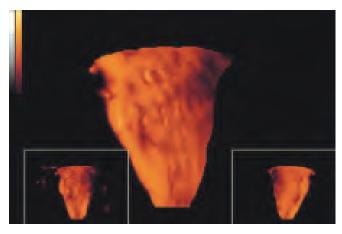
Three-dimensional power Doppler image of normal uterine cavity following injection of echogenic contrast medium. This modality facilitates visualization of the normal uterine cavity shape in frontal plane and by surface rendering
